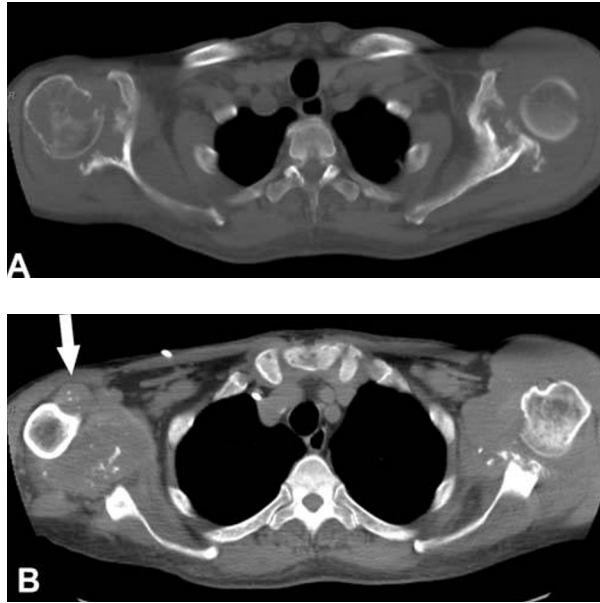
CT at the level of the shoulders, Fig 5a filmed on bone window and Fig 5b filmed on soft tissue window, a few centimeters caudal to Fig 5a. There are bilateral osseous erosions and numerous calcifications in soft tissue masses. Note the calcifications in the distended right tendon sheath of the long head of the biceps brachii muscle (arrow).
